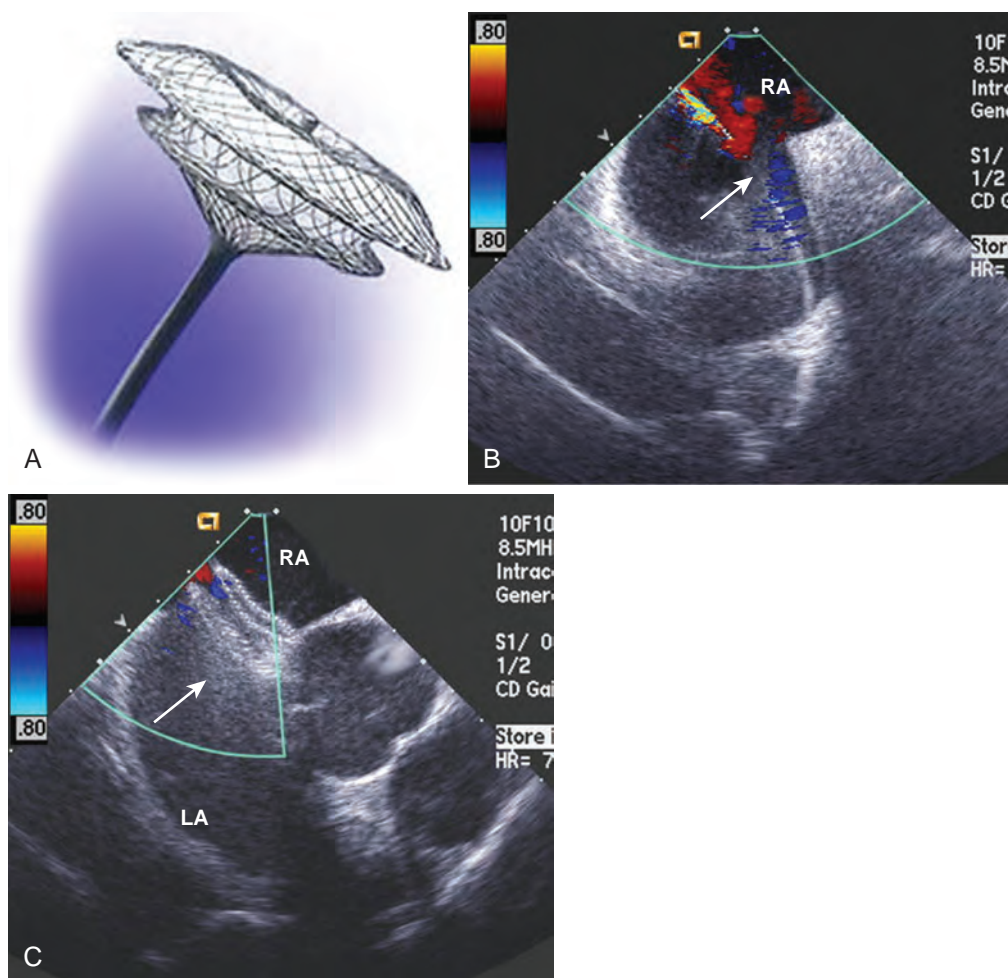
Transvenous approach to closure of atrial septal defects (ASDs). Patent foramen ovale and secundum ASDs can be closed by deploying a transvenous closure device as an alternative to surgical intervention. (A) Self-expanding Amplatzer occlusion device (AGA Medical Corporation, Plymouth, MN) that is made of wires tightly woven into two interconnected disks. The device is deployed from the femoral vein and is positioned using transesophageal echocardiography or intravascular ultrasound. (B) Color-flow Doppler image from an intravascular ultrasound scan that shows the deployment catheter as it enters through the right atrium (RA) and spans the secundum ASD (arrow). (C) Color-flow Doppler ultrasound image showing the Amplatzer device (arrow) in position across the interatrial septum, thus preventing shunt flow across the ASD. LA, Left atrium.
